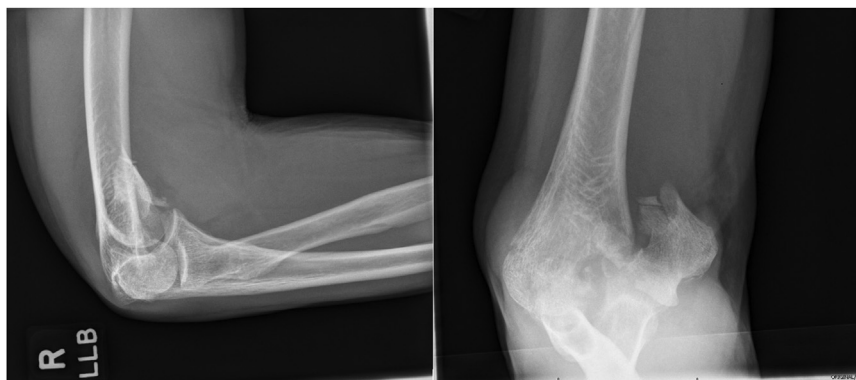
AP and lateral radiographs of the elbow demonstrating a comminuted, intra-articular distal humerus fracture. AP, anterior-posterior.
